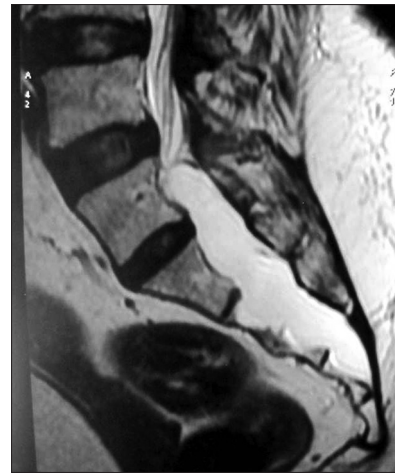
Magnetic resonance imaging scan (T2-weighted sequence, sagittal view) of the lumbosacral spine showing an intraspinal meningeal cyst extending from L5 to S4, extending into right neural foramina from L5 to S3 and left neural foramina from S1 to S3 with pressure erosion of the surrounding bone
